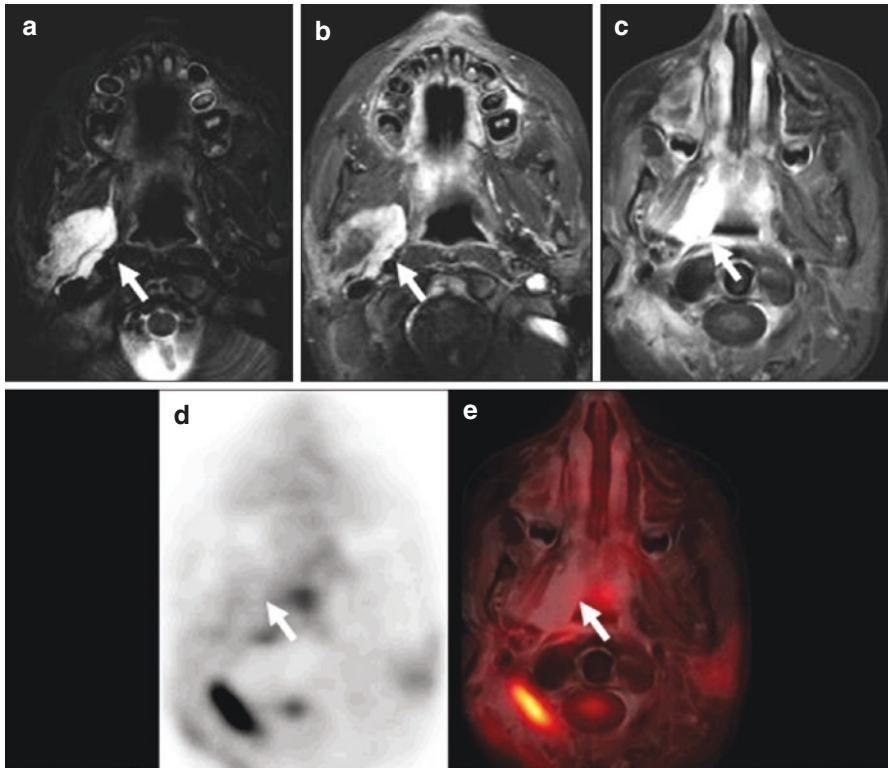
FDG-PET/MRI performed in an 8-year-old girl with right parameningeal rhabdomyosarcoma before and after therapy. Neck MRI at initial presentation (a, b) and simultaneous FDG PET/MRI (c–e) after treatment demonstrates T2 hyperintense enhancing right parapharyngeal mass (*white arrows*). PET/MRI showed persistent increased enhancing soft tissue in the right parapharyngeal resection bed (c) after resection and chemoradiation with no FDG uptake on PET (e), favored to represent non-viable tumor. Neck MRI (a) T2-weighted image; (b) T1-weighted image with contrast, PET/MRI; (c) T1-weighted images with contrast; (d) FDG PET; (e) Fused T1-weighted image with FDG PET
